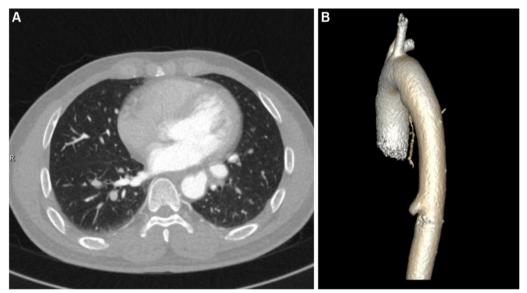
CTA of the pulmonary and bronchial arteries at 1-year follow-up: A The lung window demonstrates a slight reduction in the volume of the left lower lobe; B The aortic VR reconstruction reveals no enhancement in the distal portion of the abnormal arteries, confirming complete embolization
